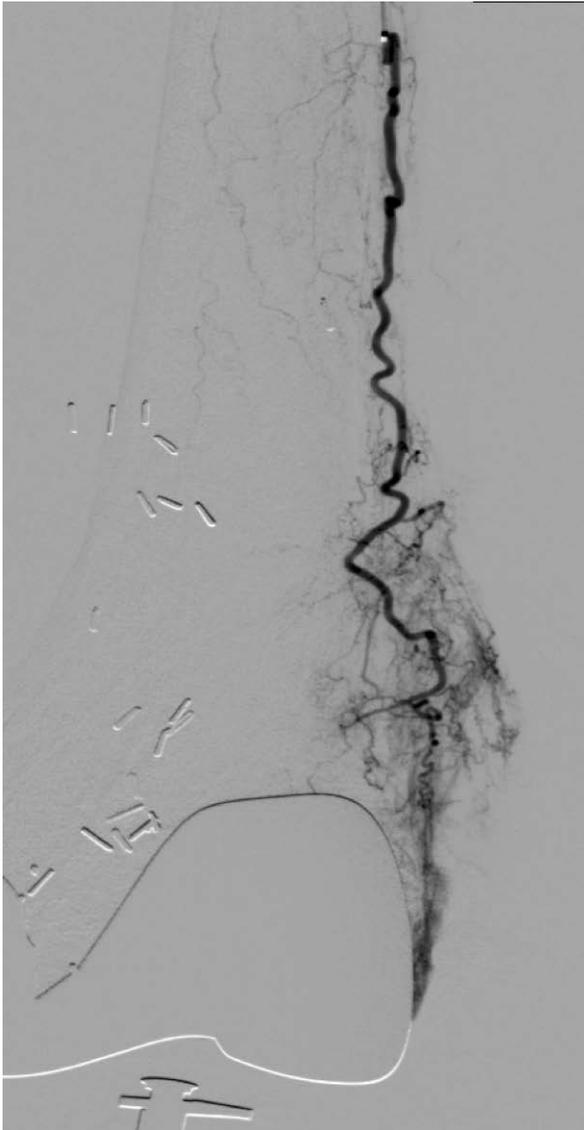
Lateral angiogram of the knee with selective catheterization of the synovial branch of the geniculate artery. In this circumstance, smaller sized embolic particles would be appropriate because cutaneous branches are not seen. This could also be verified with cone beam CT prior to embolization.
